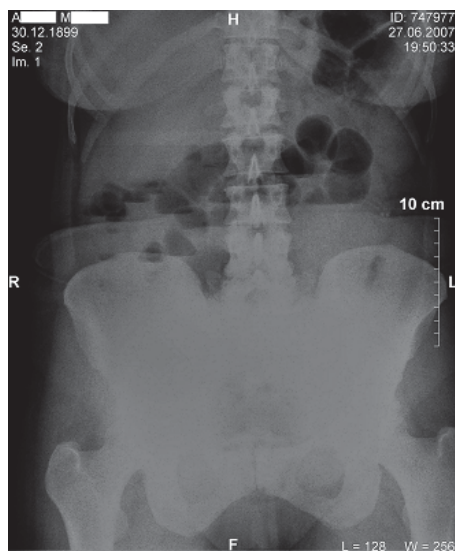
Preoperative plain abdominal radiography
